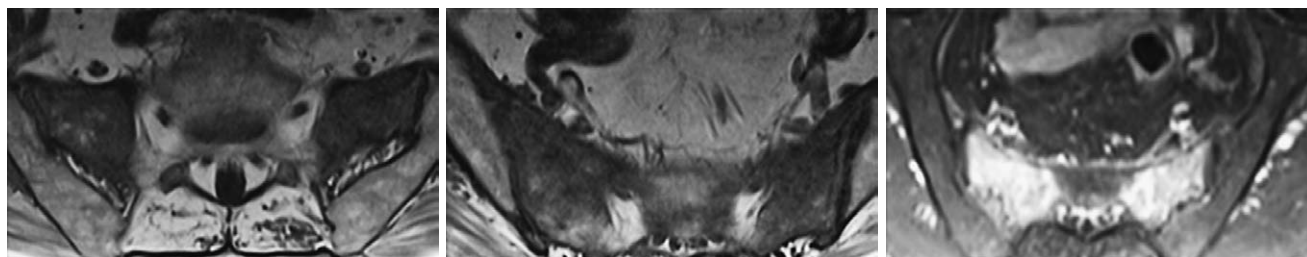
On the T1-weighted image, axial sections through the sacrum show linear zones of low signal intensity, which can be seen bilaterally in the areas extending through lateral masses of the sacrum and which correspond to fracture lines. The extensive high signal zones in the STIR image (last image on the right) correspond to the oedema of the surrounding spongy bone.
